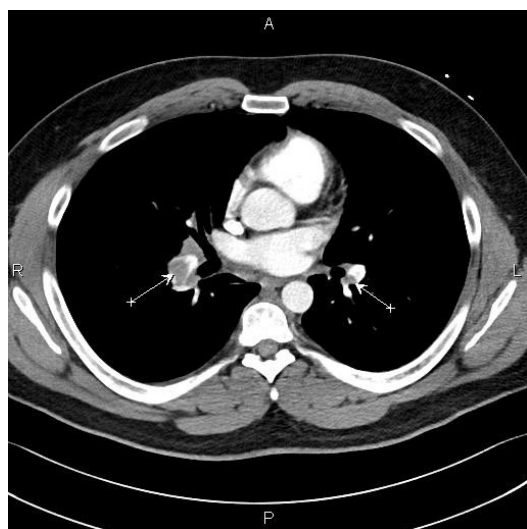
Axial contrast-enhanced computed tomography pulmonary angiography showing bilateral pulmonary arterial filling defects consistent with pulmonary emboli (arrows).
